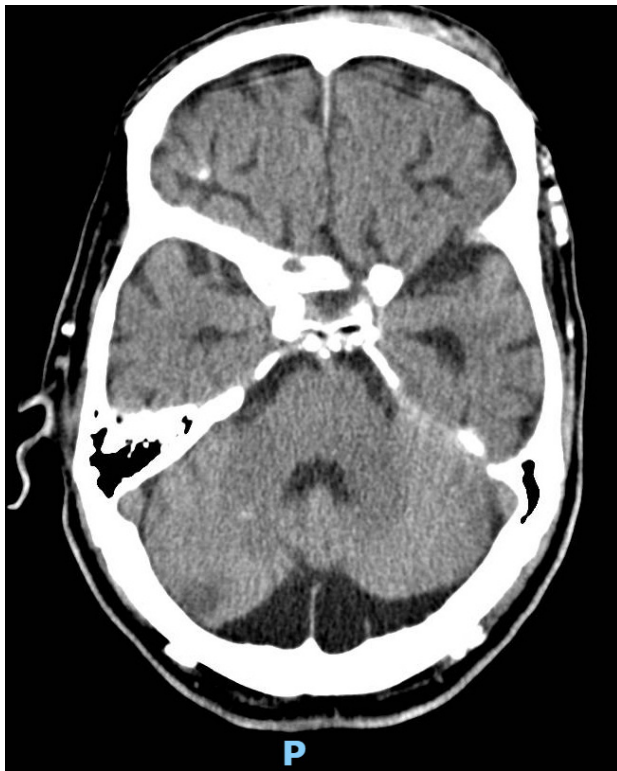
An axial CT scan of the brain shows a bilateral MCM.
